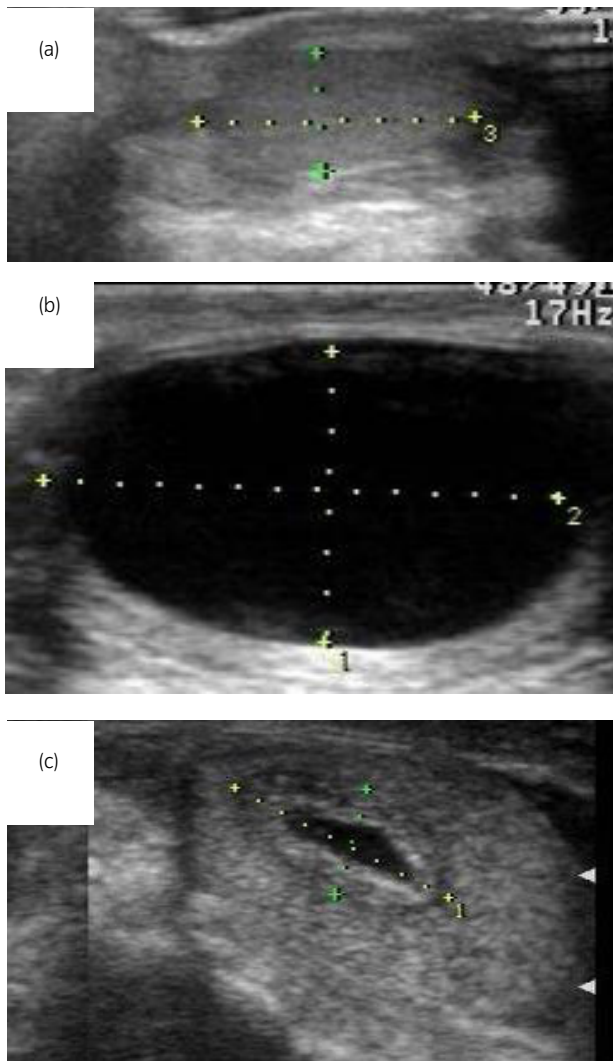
Ultrasound image in Case 6, showing a natural history of pediatric cystic teratoma (size 15×6 mm). (a) At 5 months old, when the boy presented for hypospadias, no apparent lesion was noted. (b) At 7 months old, a cyst (size 19×11 mm) appeared in the center of the left testis displacing normal tissue. (c) At 17 months, a tumorous lesion (size 11×5 mm) appeared around the regressing cyst.
